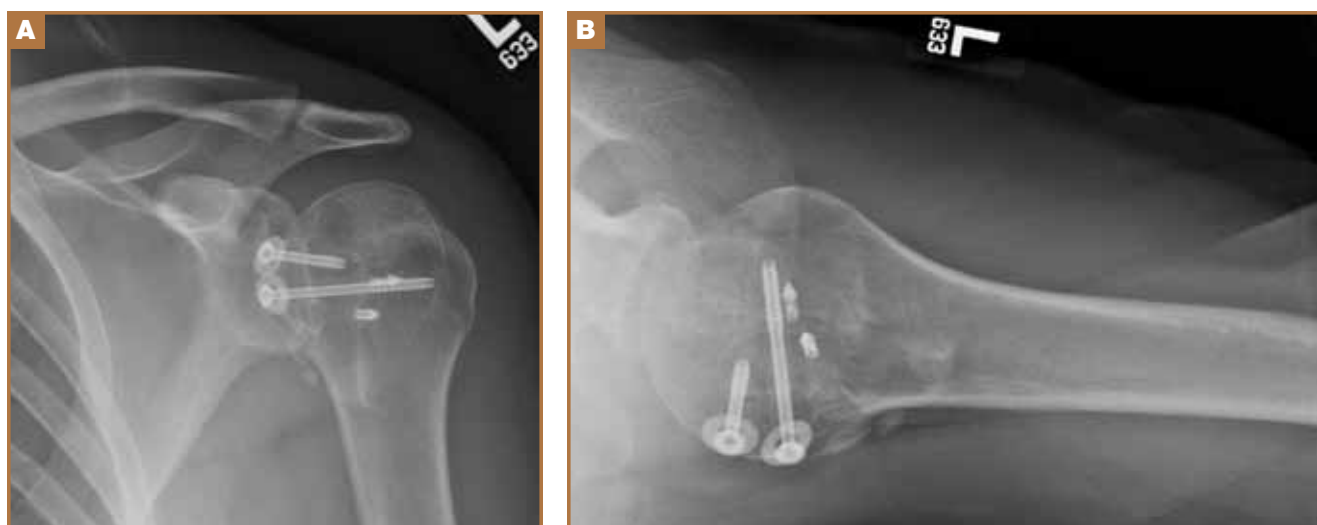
Anteroposterior (A) and axillary (B) radiographs of the left shoulder performed 6 months postoperatively, demonstrating that fragment fixation and glenohumeral reduction are maintained.
